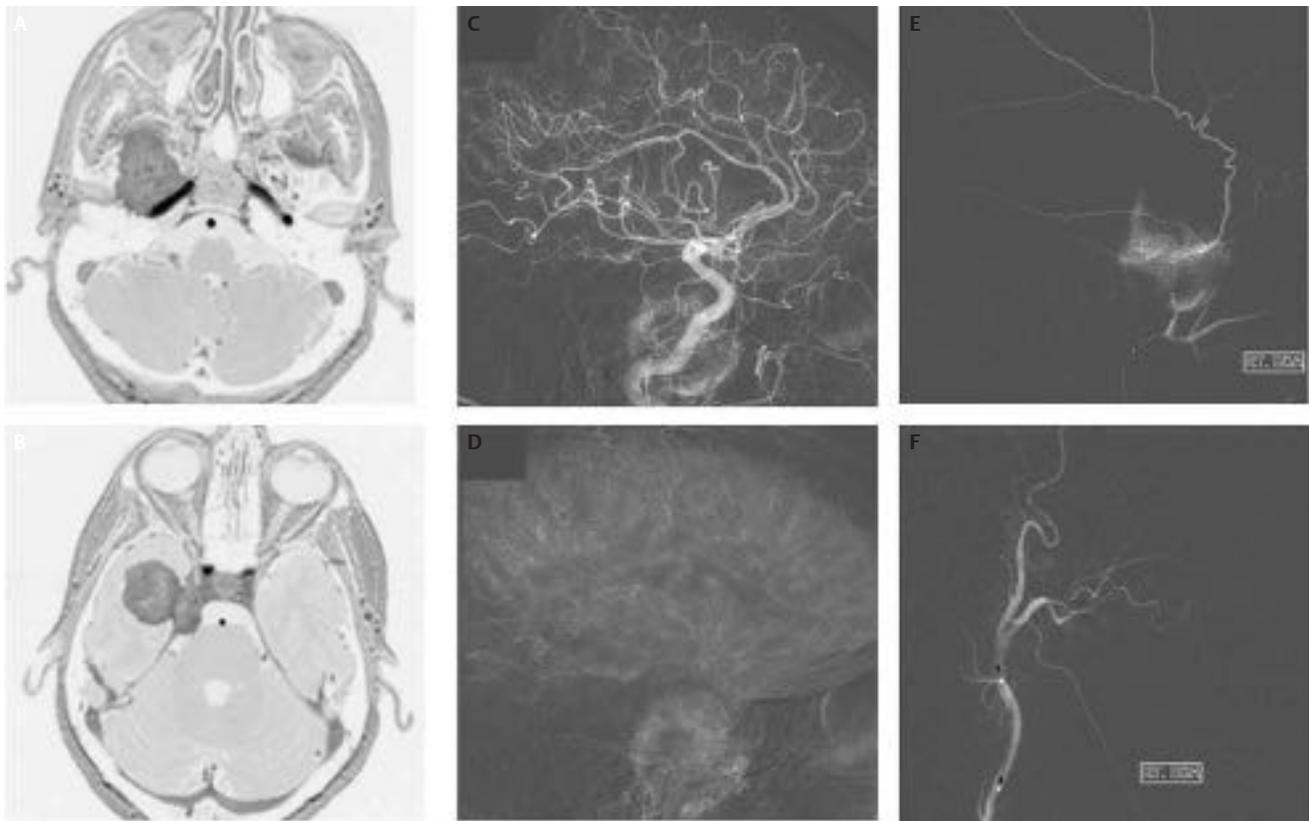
Right inferior temporal meningioma. (A,B) Axial magnetic resonance images. (C) Arterial and (D) venous phase right common carotid artery angiograms demonstrating a large round tumor blush centered in the right inferior temporal region. (E) Superselective lateral right internal maxillary artery angiogram demonstrating significant vascular supply from the middle meningeal and accessory meningeal arteries. (F) Postintervention angiogram of the right external carotid artery after embolization with polyvinyl alcohol particles followed by platinum coils. Note the absence of appreciable residual tumor blush.
